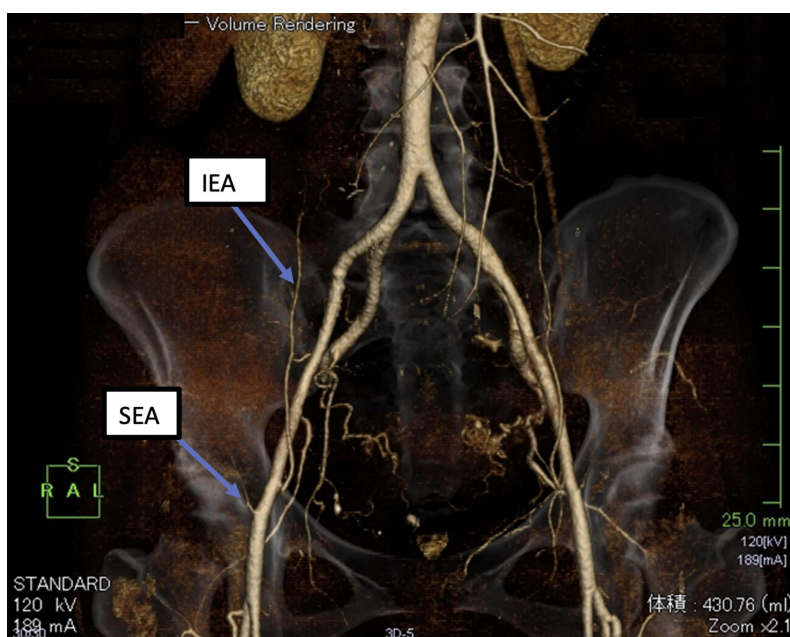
3D CT of the vascular anatomy of the abdomen. The right inferior epigastric artery (IEA) is easily identified but the right superficial epigastric artery (SEA) is not visible where it arises from the femoral artery.
